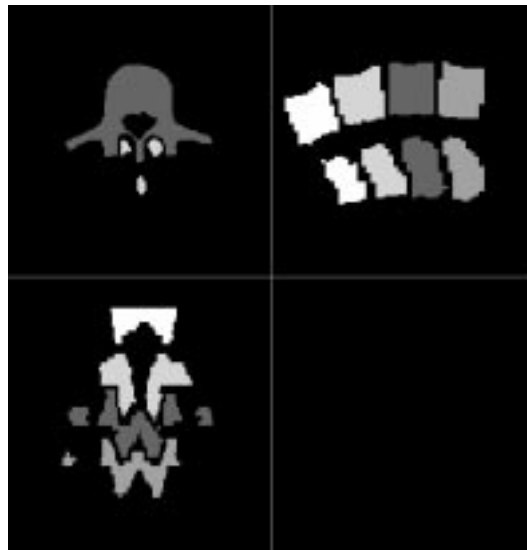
Axial, sagittal and coronal sections through a segmented CT image which contains four lumbar vertebrae, L1 \rightarrow L4.
